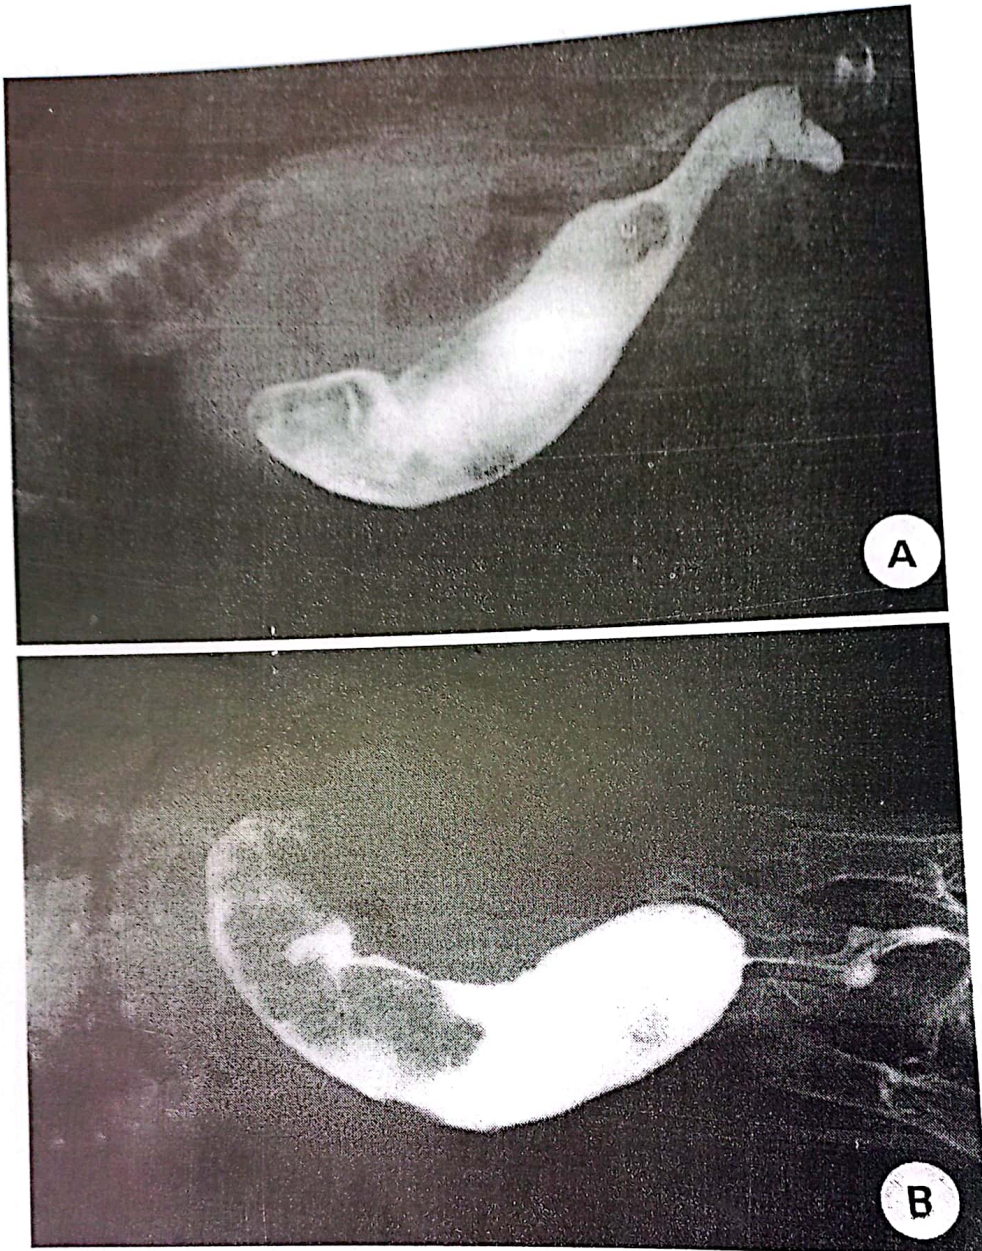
Contrast barium enema; Lateral and ventrodorsal X-ray images of the previous case in Fig. (7). Note, the dilated colon and the relative stenosis of the pelvic canal.
